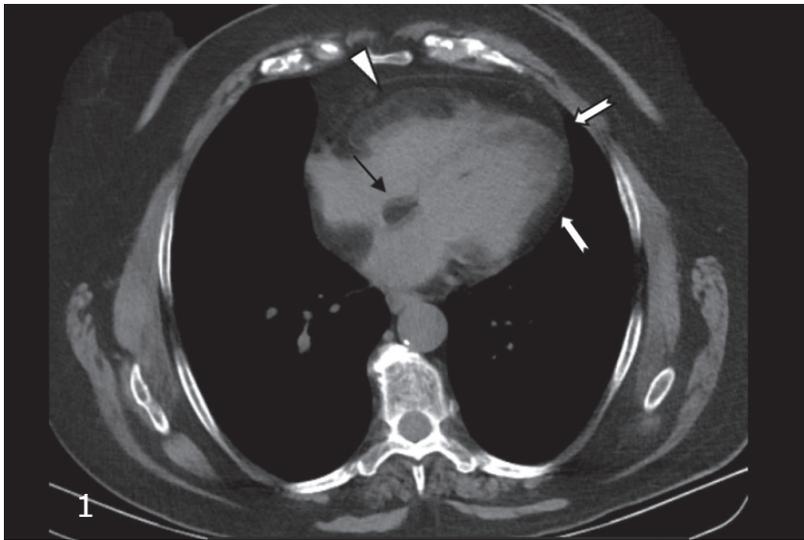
Axial non contrast CT image demonstrate dumbbell hypertrophy of the interatrial septum (2cm) due to fat deposition (negative attenuation values) (→). Extensive intramyocardial fat deposition is also observed in the subepicardial and midmyocardial layers of RV free wall (▷), as well as in the apex and in the lateral wall of the LV (⇔).
